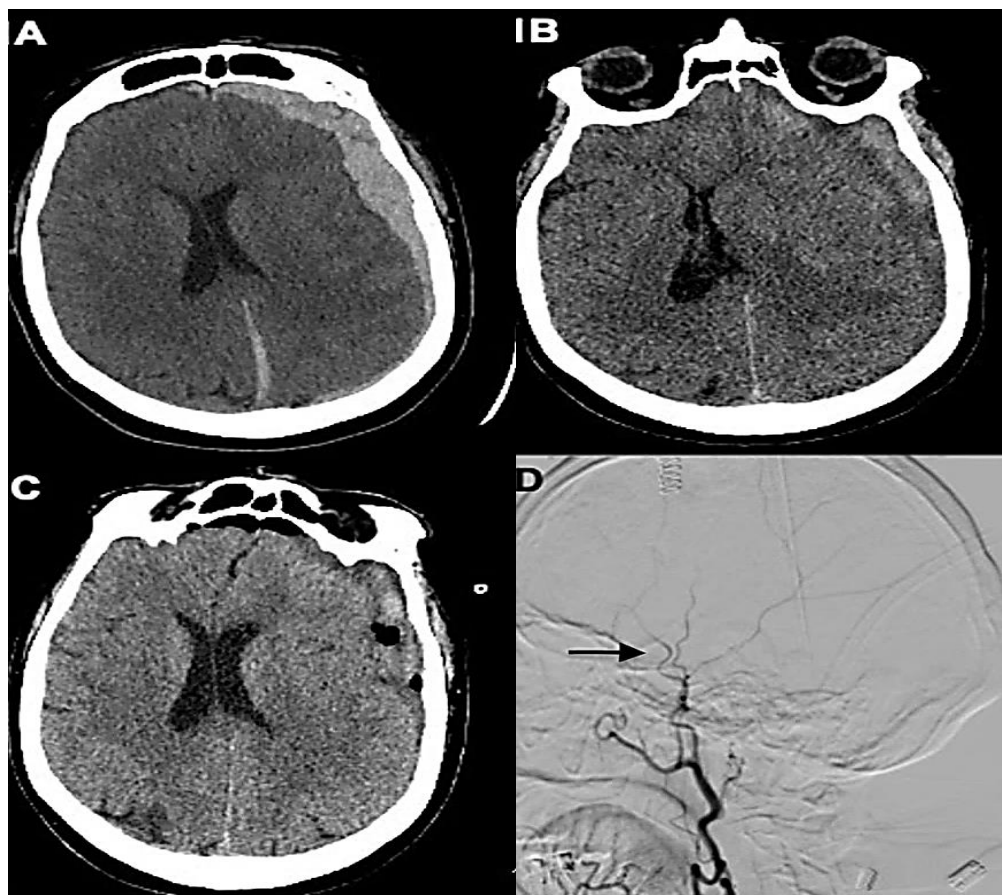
A) Axial head computed tomography (CT) scan showing left subdural haemorrhage (SDH) with midline shift; B) Subacute SDH with increased midline shift; C) Post hematoma evacuation head CT; D) Lateral digital subtraction angiography image showing external cerebral artery and its branches including middle meningeal artery (MMA) (black arrow)
